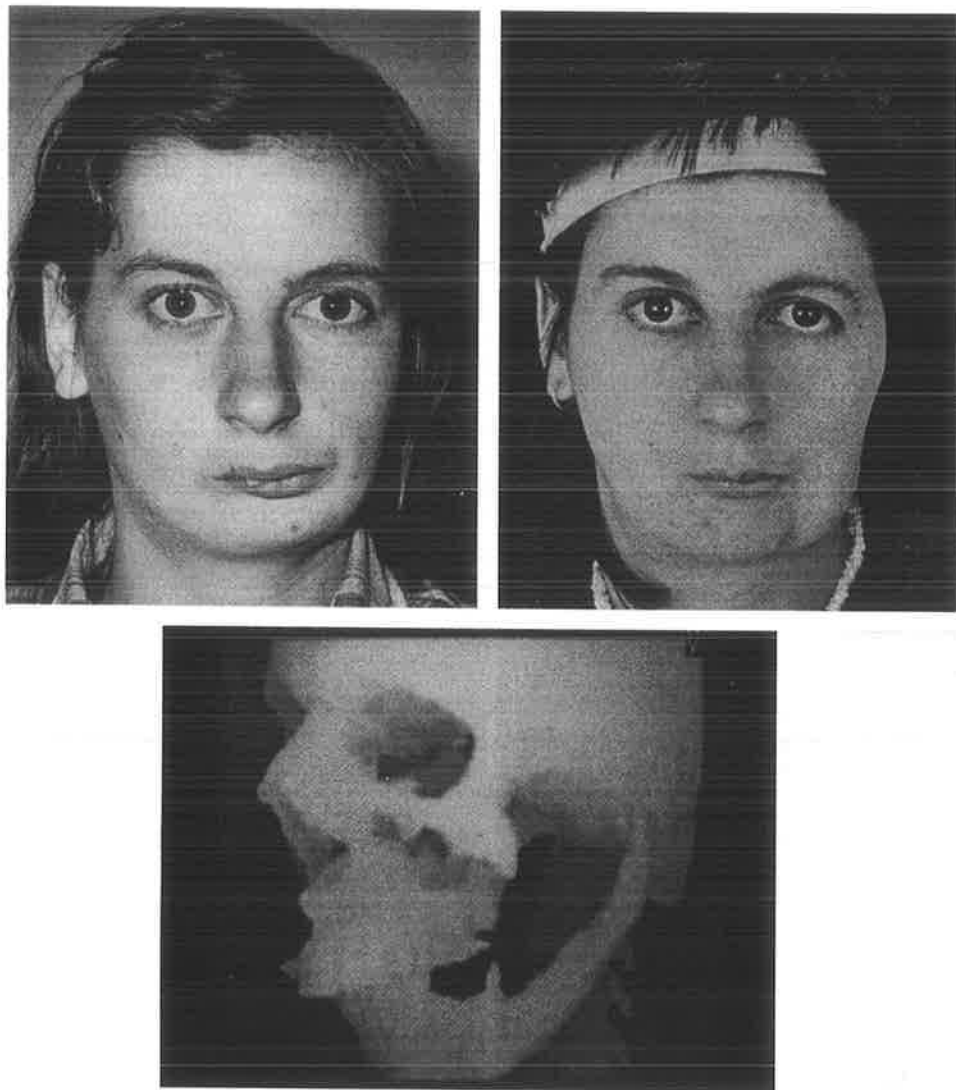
Case 1. A 14-year-old girl with hemifacial microsomia showing preoperative (above, left) and postoperative (above, right) appearance and three-dimensional CT scan (below) of the reconstructed left hemimandible 10 years later.
